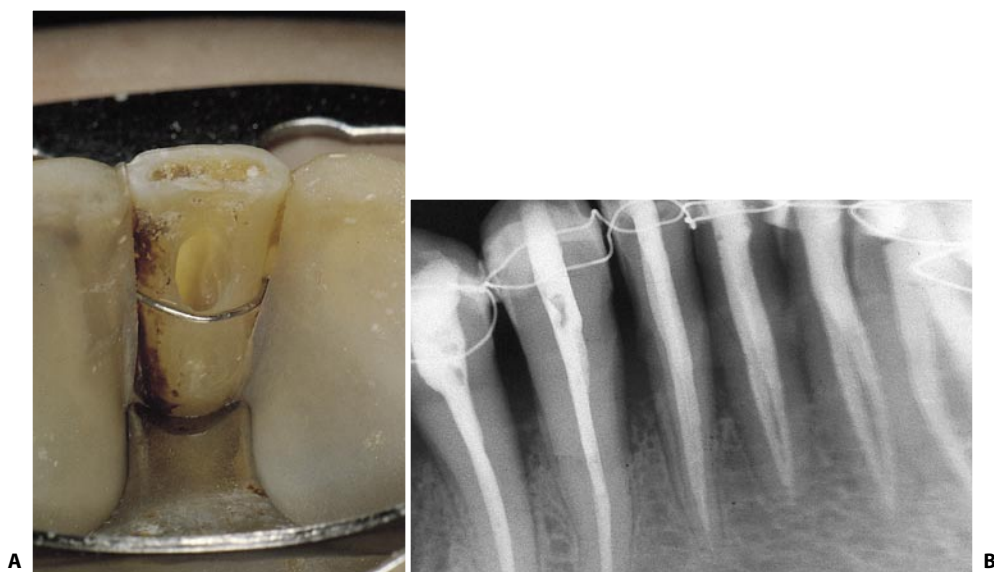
The four lower incisors of this patient all have two canals. A. Elliptical access cavity. B. Postoperative radiograph. The presence of two canals is easily documented in the left incisors, which have been radiographed in a mesiodistal view.
